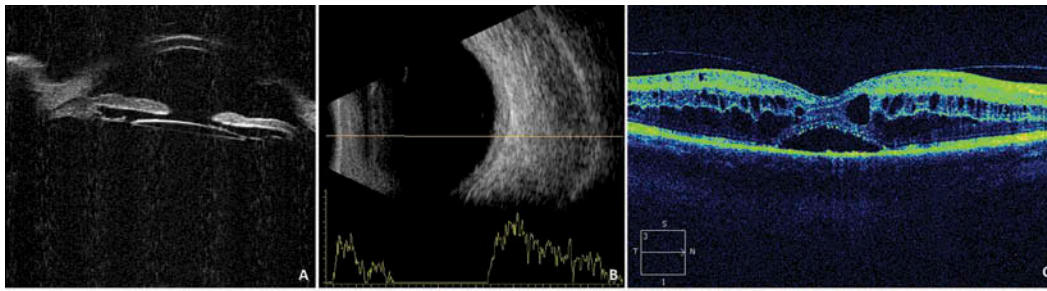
(A) OD. UBM ruled out detachment of the ciliary body. (B) OD. B-scan ultrasound revealed choroidal thickening. (C) OD. OCT revealed CME and serous retinal detachment.
